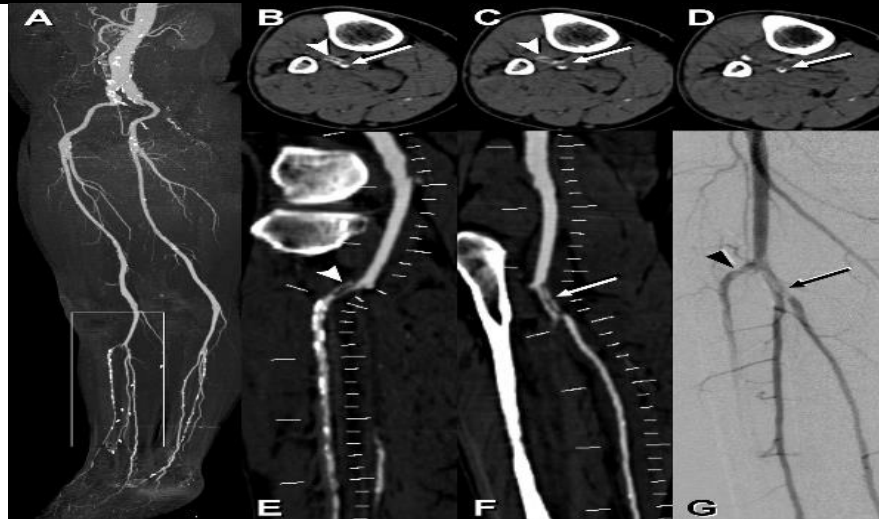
(a) Oblique (45° left anterior oblique) MIP image of entire data set. Box indicates magnified views. (b–d) axial CT images through the right proximal calf show embolic filling defects in the anterior tibial artery (arrowheads) and the tibioperoneal trunk (arrows). (E, f) Corresponding CPR images from the popliteal artery through the anterior tibial artery (e) and posterior tibial artery (f) display intraluminal filling defects. DSA confirms CT angiography findings (g) ⁽²⁸⁾.
